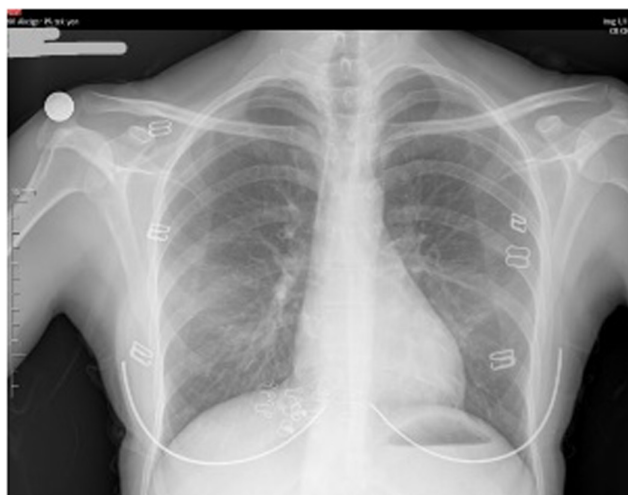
The X-ray after 10 days of treatment.
